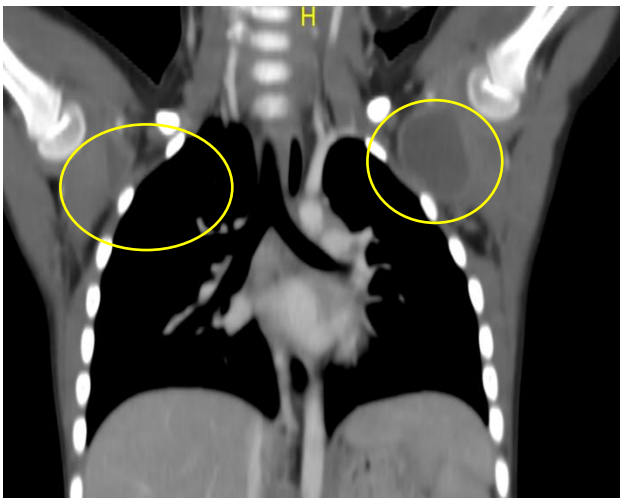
CT thorax showing bilateral shoulder joint abscesses.¹¹
